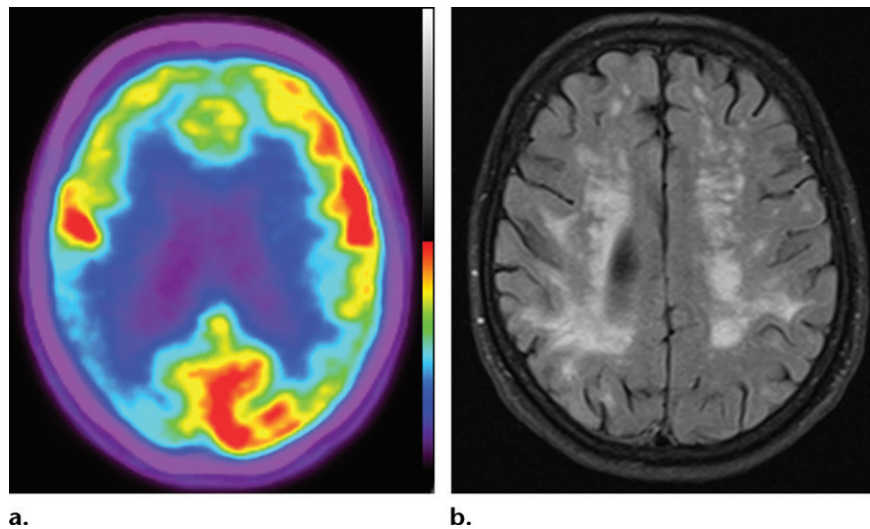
Patient with vascular dementia. (a) Axial ¹⁸F-FDG PET image shows decreased activity in the bilateral frontal and parietal regions, with the right side being worse than the left. In the proper clinical setting, these findings are suggestive of Alzheimer disease dementia. (b) Corresponding axial MR image shows confluent T2-weighted fluid-attenuated inversion-recovery (FLAIR) white matter areas of hyperintensity extending to the subcortical regions, reflecting extensive ischemic damage without cortical volume loss. Findings at structural and functional imaging are representative of subcortical arteriosclerotic encephalopathy or Binswanger disease.
